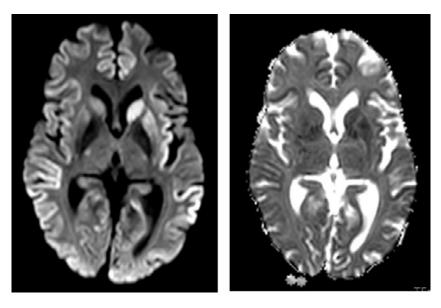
MRI brain (DWI-ADC) showing areas of signal hyperintensity in cortical regions.
